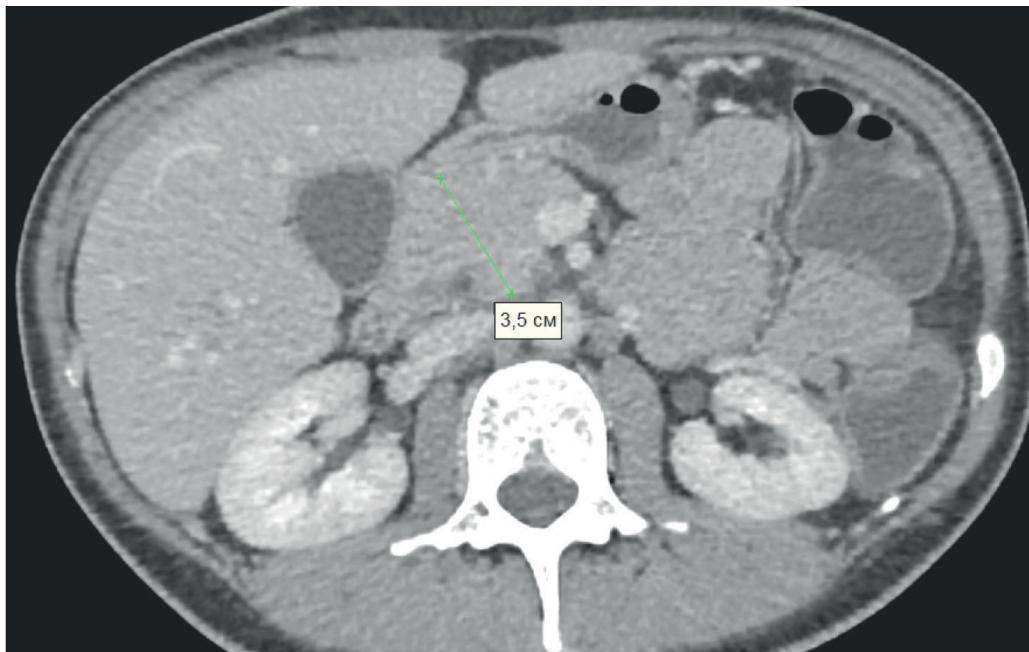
CT scan (June 2023): the pancreas is uniformly contrasted, the head is enlarged to 35 mm
